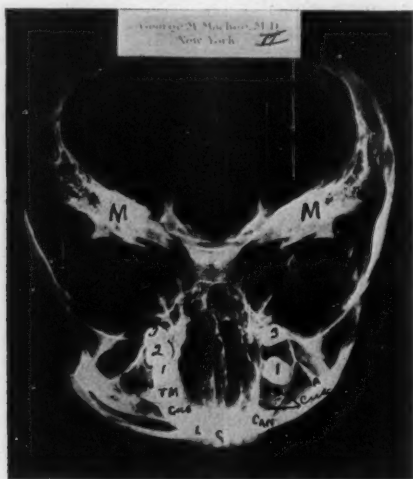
X-ray photograph showing bowing of septum. Note shortness of alveolar process. Same skull as Figure 6.
